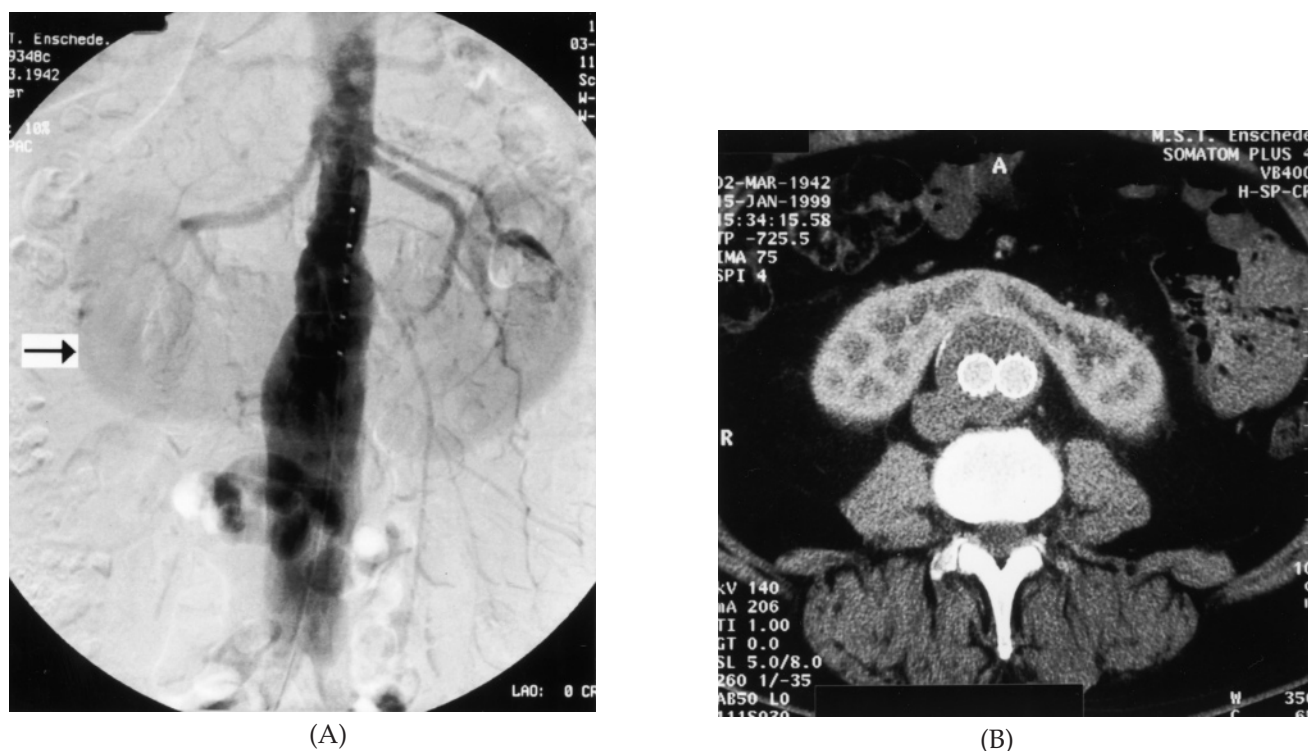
(A) Preoperative intra-arterial abdominal angiography. Arrow indicates horseshoe kidney. (B) Postoperative spiral CT scan. Bifurcated stent graft is centrally placed in the abdominal aortic aneurysm with, in front, the horseshoe kidney showing homogenous contrast enhancement.
